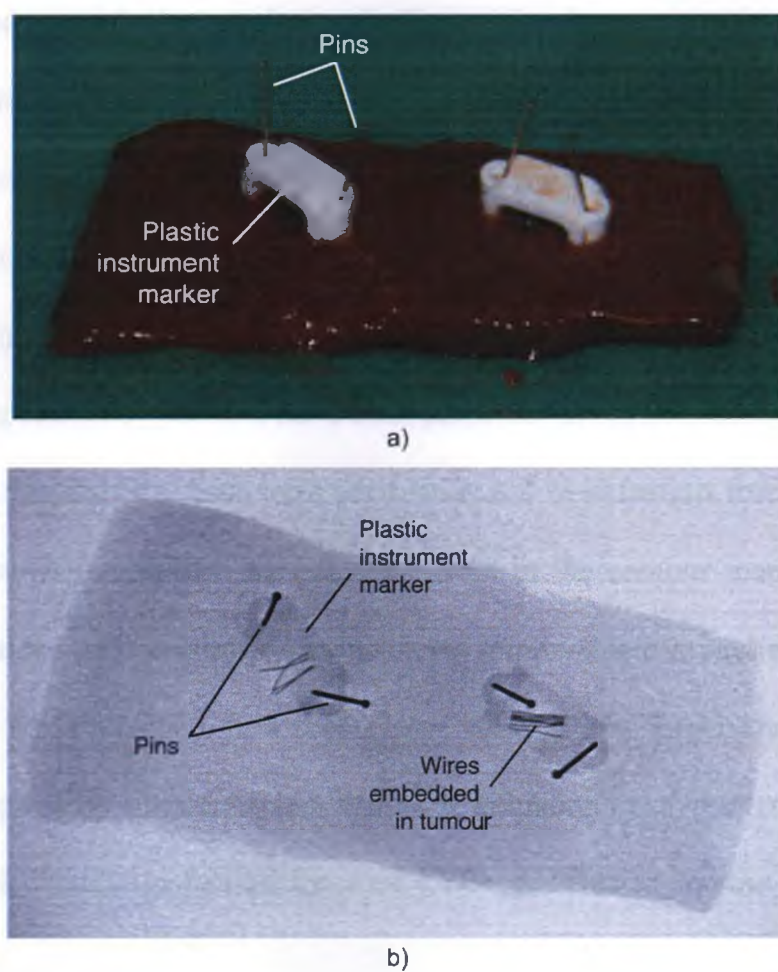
(a) Manually palpated tissue with each suspected tumour site marked by a plastic instrument marker held in place with two pins. (b) Radiograph of tissue, showing 10 mm tumours with embedded wire and plastic instrument markers.
